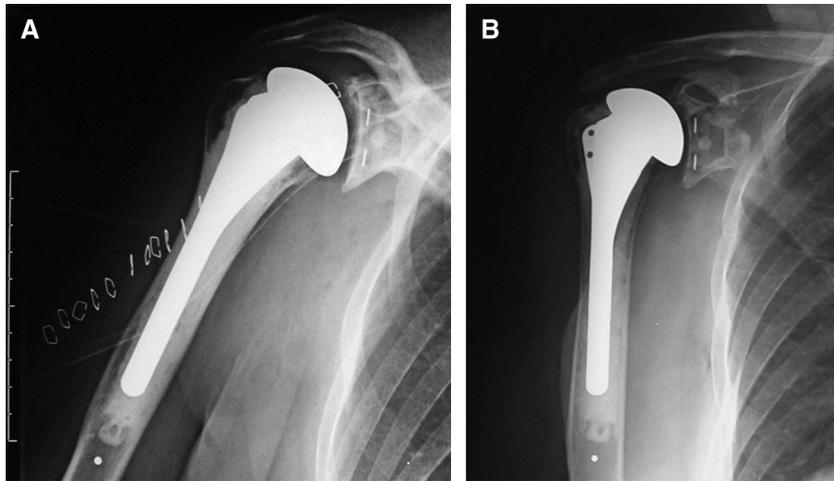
Anteroposterior radiographs of an anatomically positioned humeral component. (A) On the radiograph obtained immediately postoperatively, the humeral component is well seated, does not overhang the metaphysis, and appears appropriately sized. (B) Repeat radiograph obtained at 117 months postoperatively shows only minimal radiolucency around the glenoid implant. The patient's adjusted Constant score was 100.
